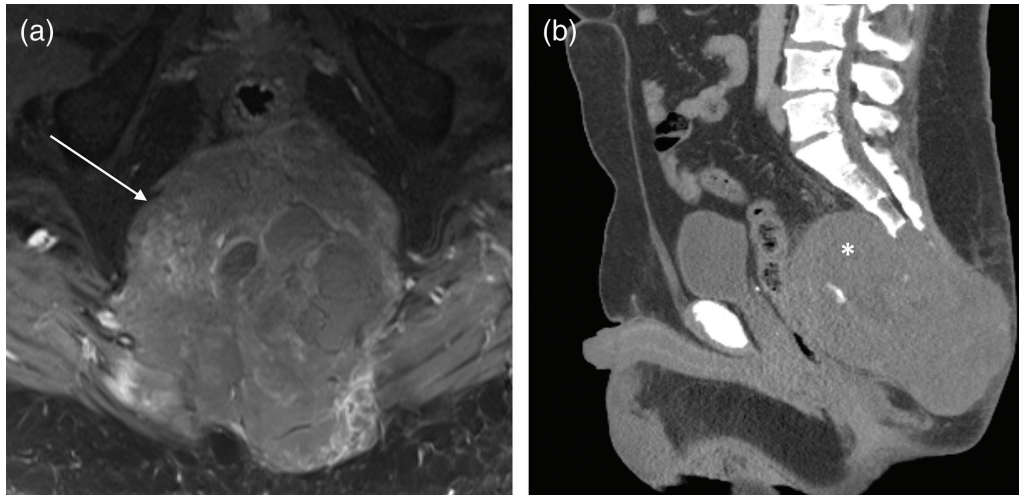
Representative axial MRI image (a, arrow) and sagittal CT image (b, *) showing the large sacral chordoma.
